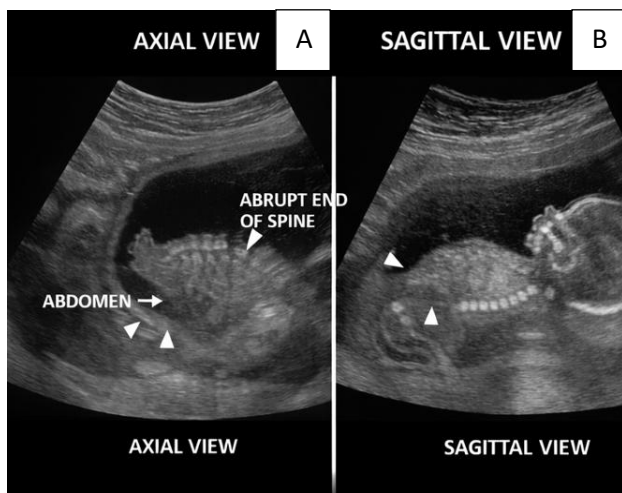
(A and B): Ultrasound of a 20-week fetus with CRS.
